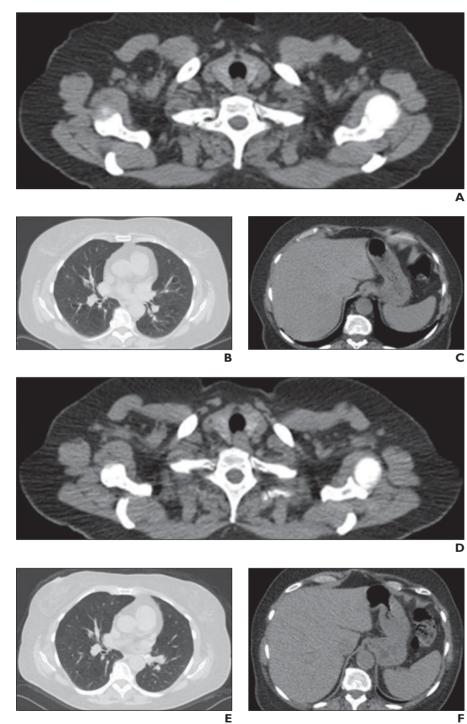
A 65-year-old woman with body mass index of 29 who underwent scanning before and after CT protocol optimization. Same slice locations in upper thorax, lungs, and abdomen are shown for comparison.
